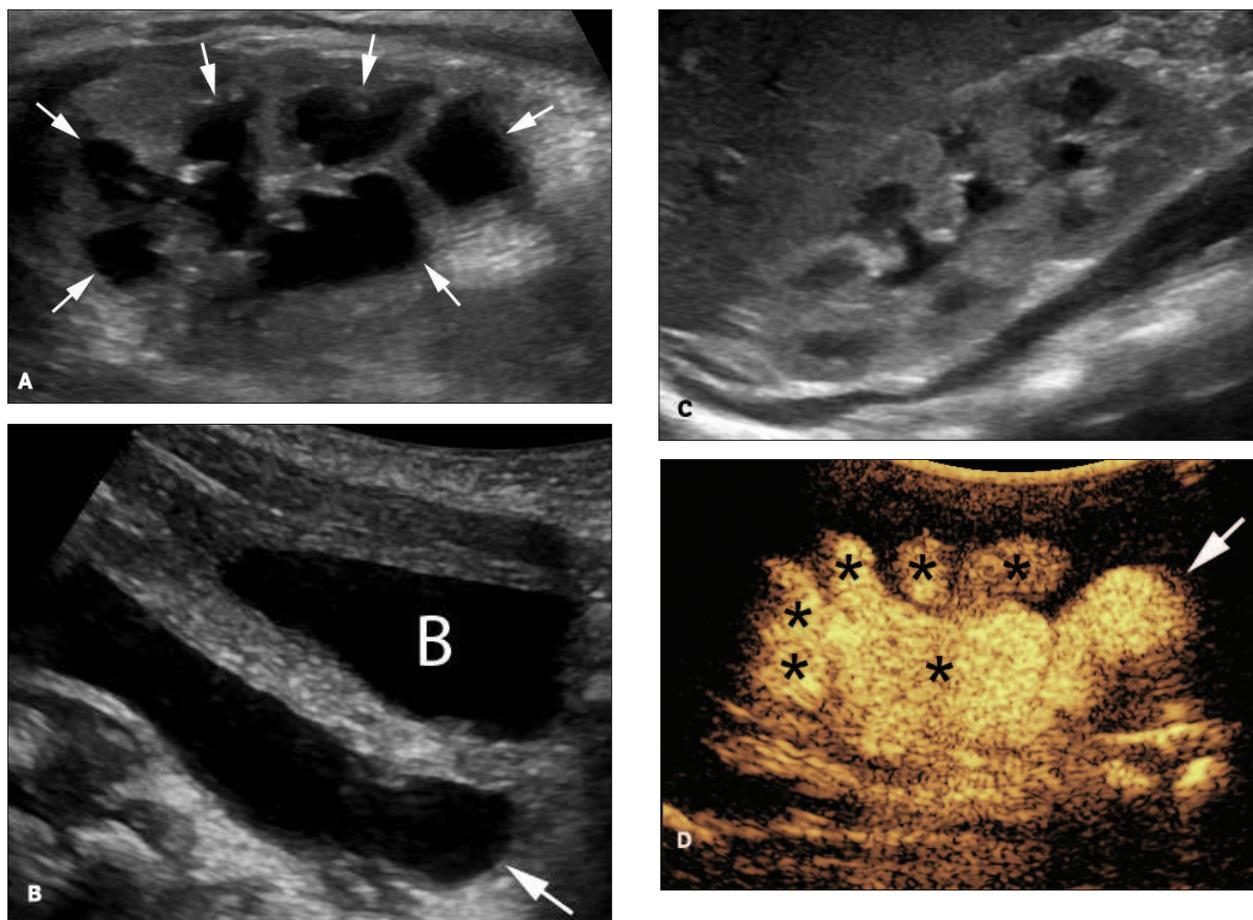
Case 3. A. Sagittal sonogram reveals mild-to-moderate dilation of the left renal collecting system (arrows). B. Sagittal sonogram depicts moderate-to-severe dilation of the distal left ureter (arrow) posterior to the bladder (B). C. Normal sagittal sonogram of the right kidney. There is no ureteral dilation. D. Sagittal sonogram of the left flank during contrast-enhanced voiding urosonography shows contrast material filling a dilated ureter (arrow), a dilated renal pelvis, and dilated, blunted calyces (asterisks). There is no IRR, and the surrounding renal parenchyma is dark. (continued)
